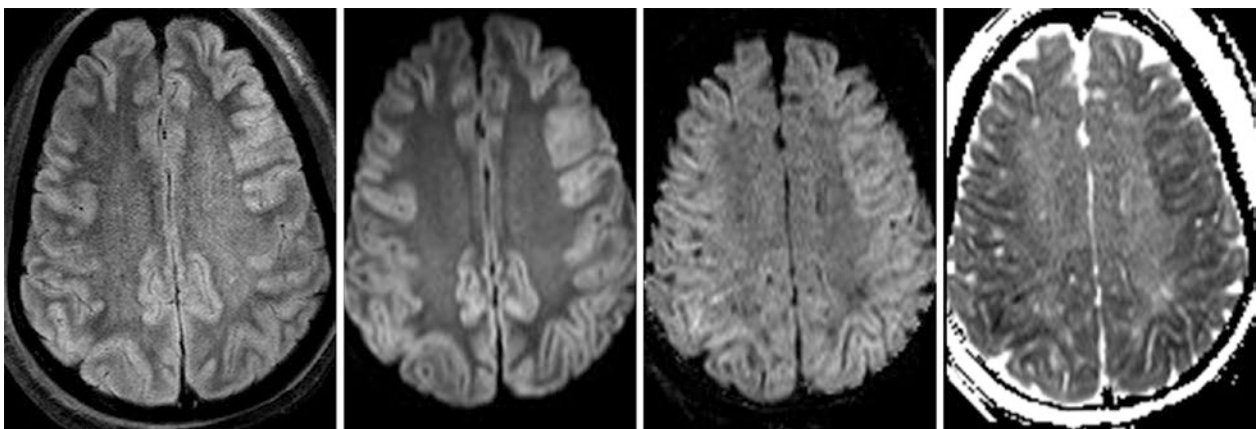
Comparison case of hypoxic ischemic encephalopathy (HIE) in a 58-year-old after an overdose of sedatives. A 3 T MRI showed mild, diffuse cortical edema on FLAIR (*left*) and DWI (*left*
